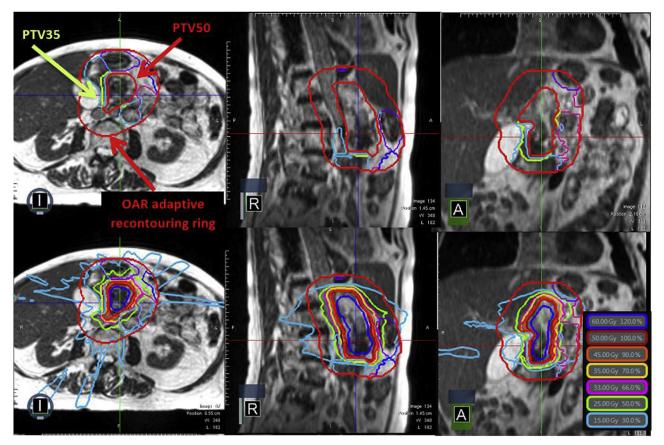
Target volumes (top row) and isodose lines (bottom row) for a pancreas cancer patient prescribed 50 Gy in 5 consecutive fractions with daily magnetic resonance image guidance and on-table adaptive replanning. *Abbreviations*: OAR organs at risk; PTV = planning target volume.
